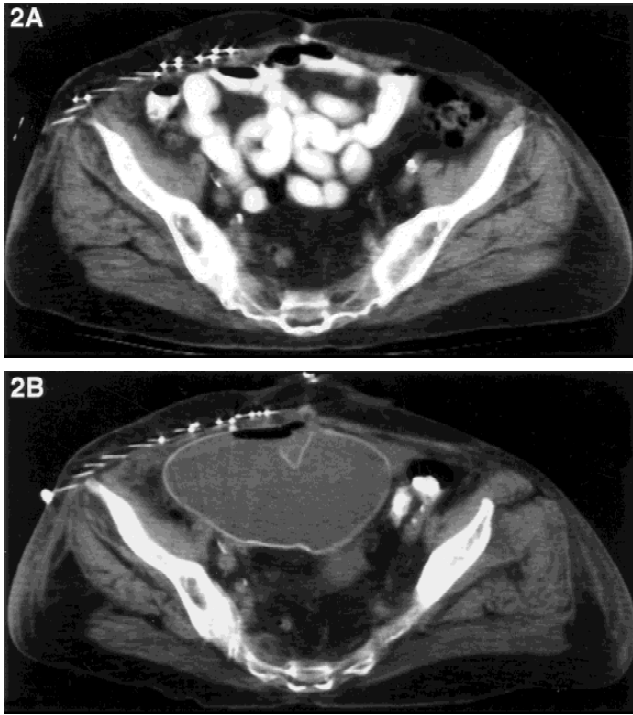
A. CT Scan after resection of abdominal wall tumor showing close relationship of brachytherapy catheters (prior to loading) and previously irradiated bowel (patient 2). B. CT scan showing displacement of previously adjacent bowel and brachytherapy catheters by breast implant (patient 2).
